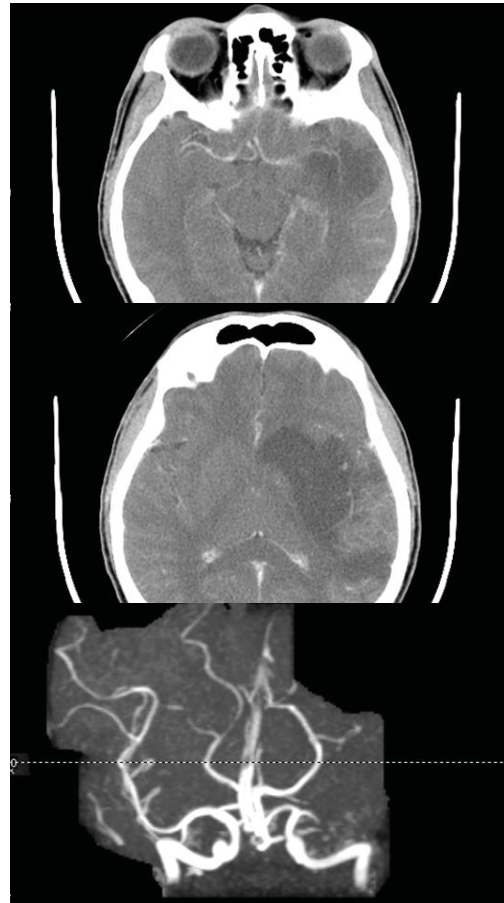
CT brain scan showing hypodense lesion in left frontoparietal region and magnetic resonance angiogram showing occlusion of left middle cerebral artery.
